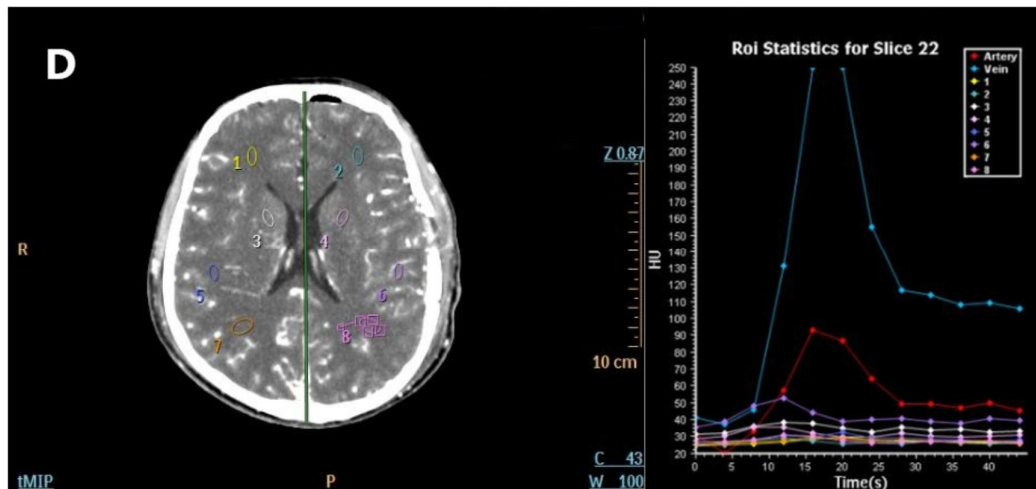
Computed tomography angiography (CTA) and CT perfusion (CTP): (A) pre-operative CTA. (B) two weeks post-operative CTA showed newborn compensatory proliferated vasculature. (C) preoperative CTP. (D) two weeks post-operative CTP showed increased cerebral blood flow.
